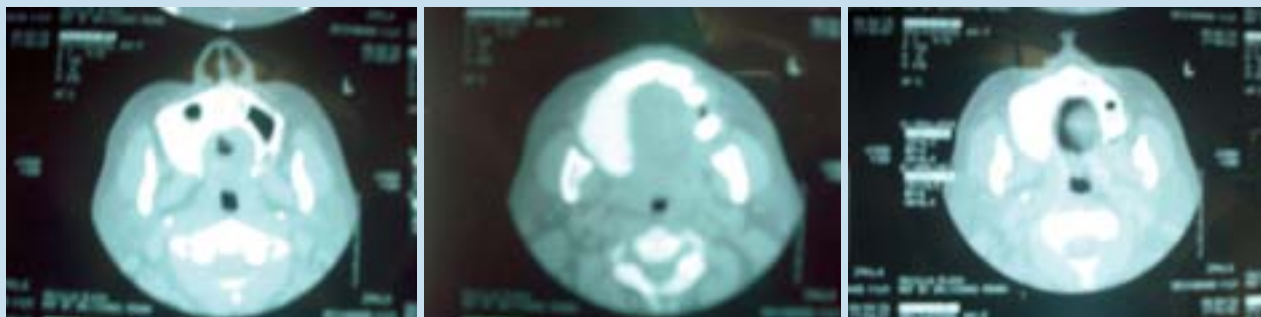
Pre-operative axial CT scans showing the lesion on the right maxilla
